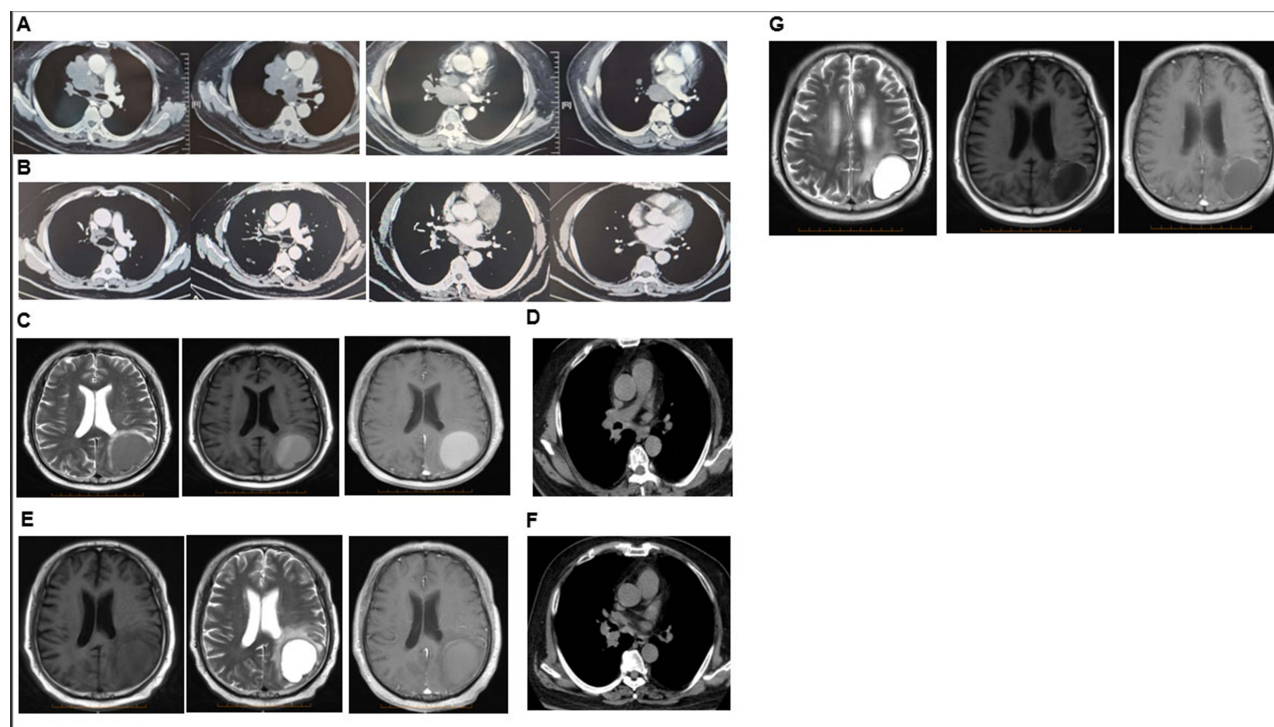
Baseline before immunotherapy. (A) 2 cycles after immunotherapy. (B) November 2021, cystic brain metastasis. (C) February 2022, 3 months after cystic brain metastasis. (D) February 2022, chest CT after radiotherapy for brain lesions. (E) May 2022, chest CT of recurrence of the right hilar of the right lung nodules. (F) November 2022, 1 year after cystic brain metastasis. (G).
